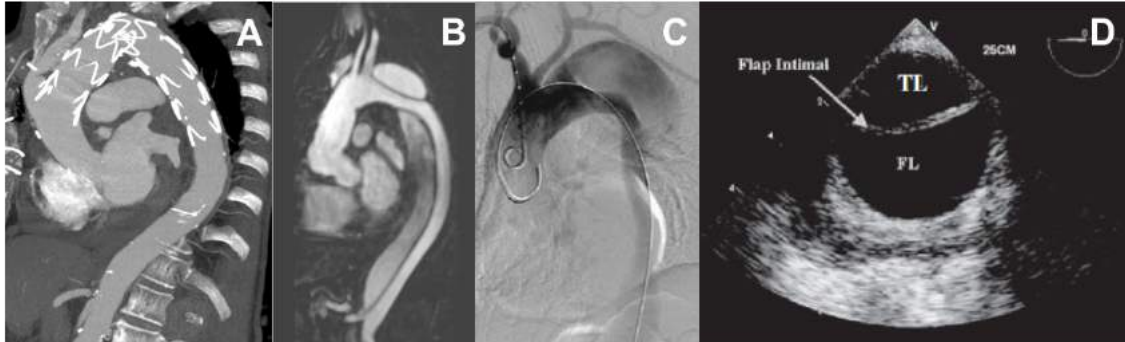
Examples of vascular imaging methods. (A) Post-operative CTA, (B) MRI showing a dissected aorta (reproduced from Sherrah et al. [2015]), (C) intra-operative angiography, (D) intra-operative trans-esophageal echocardiography which shows dissection intimal flap between true and false lumen (reproduced from Júnior et al. [2011]).
